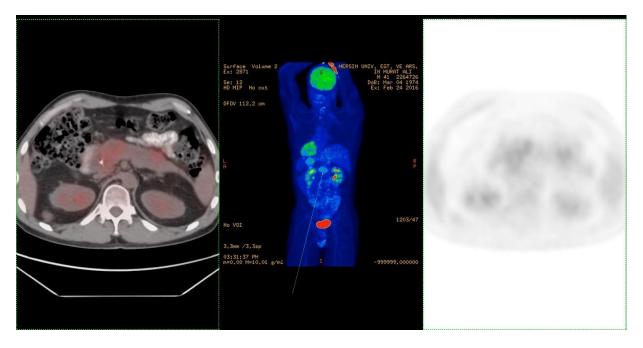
In a 41-year-old male patient with lung cancer, a distinct mass lesion in the head of the pancreas (yellow arrow) and hypermetabolic thickenings in the anterior part of the tail (red arrow) were detected on PET/CT transaxial fusion (A), MIP (B) and PET (C) images, indicating metastasis. was interpreted as suspicious. When the patient developed malignant biliary stenosis, the lesion was evaluated by biopsy. The biopsy result was reported as primary pancreatic adenocarcinoma.
